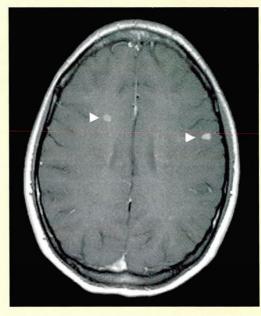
Left, T2-weighted magnetic resonance image of a 25-year-old woman with a 5-year history of relapsing-remitting multiple sclerosis. Right, gadolinium-enhanced T1-weighted image of the same patient. Some of the T2 lesions exhibit gadolinium enhancement.
